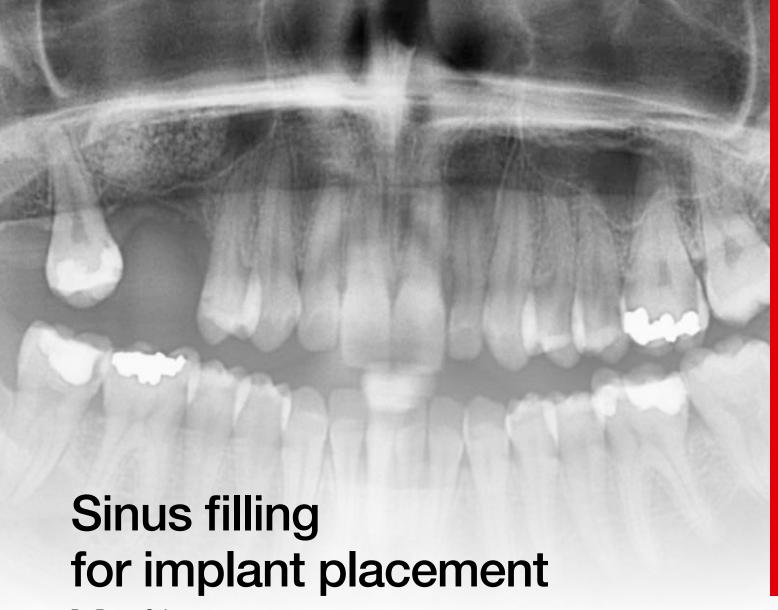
6 month follow-up - Radiography shows significant bone gain. Implant placement can now be considered under optimal conditions.
